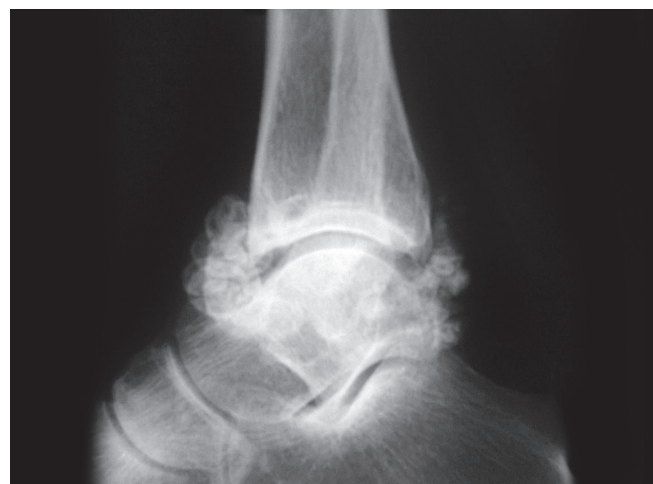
Pre-op X-ray lateral view
